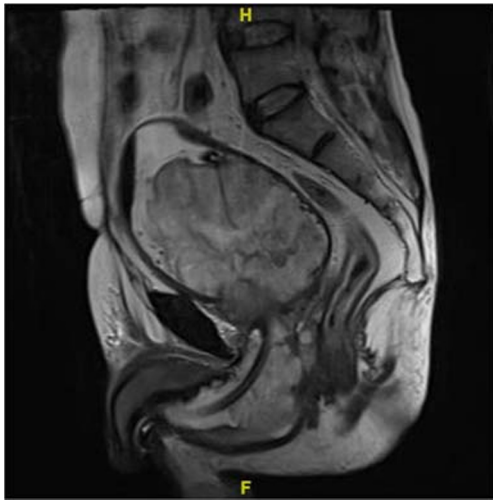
MRI pelvis showing bladder and concomitant urethral growth
